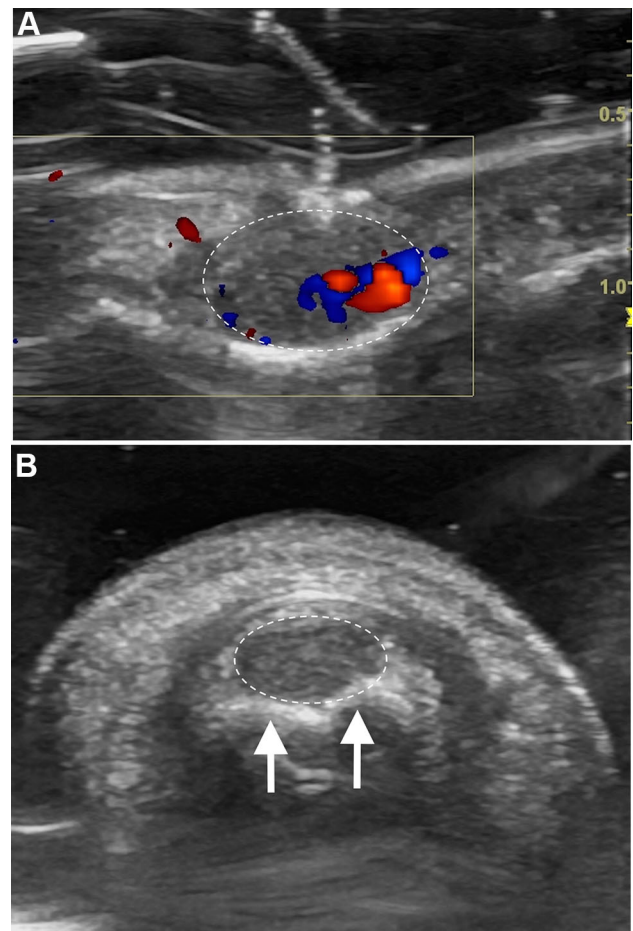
Glomus. Ultrasound a longitudinal and b transverse views. A hypoechoic, hypervascular lesion (*pointed line*), located in the proximal third of the nail bed. There is also signs of chronicity with mild erosion of the proximal third of the phalanx (*arrow*)
